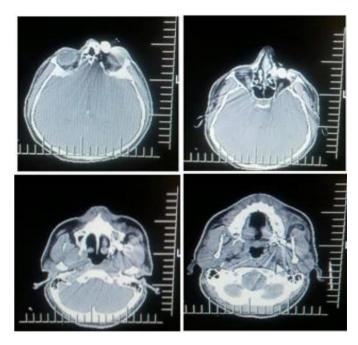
Computed tomography (CT) scan showing foreign body penetrating left maxillary sinus towards left petrygopalatine fossa
